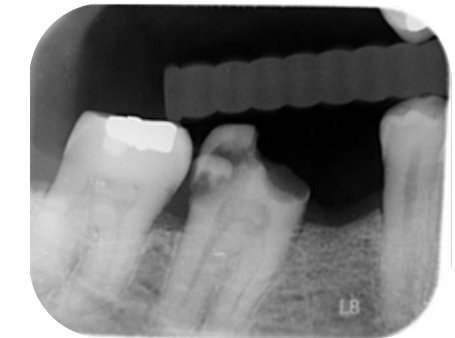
Periapical radiograph of tooth 46 (partially diagnostic/incomplete image of apex) obtained from the private dental practitioner taken 1 day prior to consultation. The radiograph revealed significant distal caries progression extending into the pulp.
